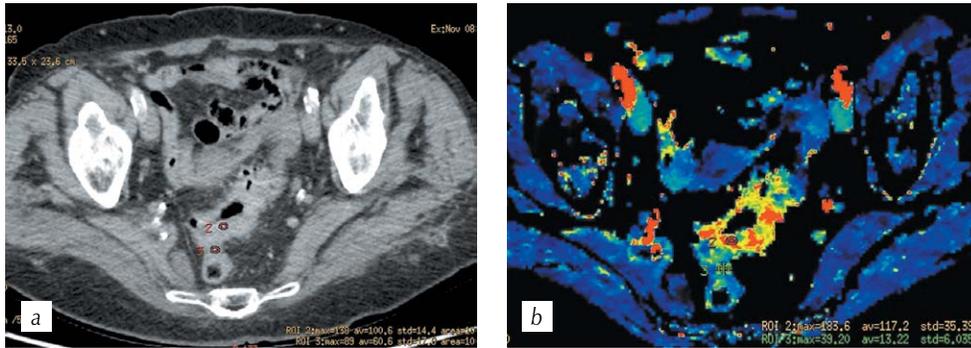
HCT, multiplanar reconstruction in the axial plane in the portal phase (a) and CT perfusion, parametric map of the blood flow (b) with ROI 2 in the invasive part of the tumor and ROI 3 in the intact intestinal walls
